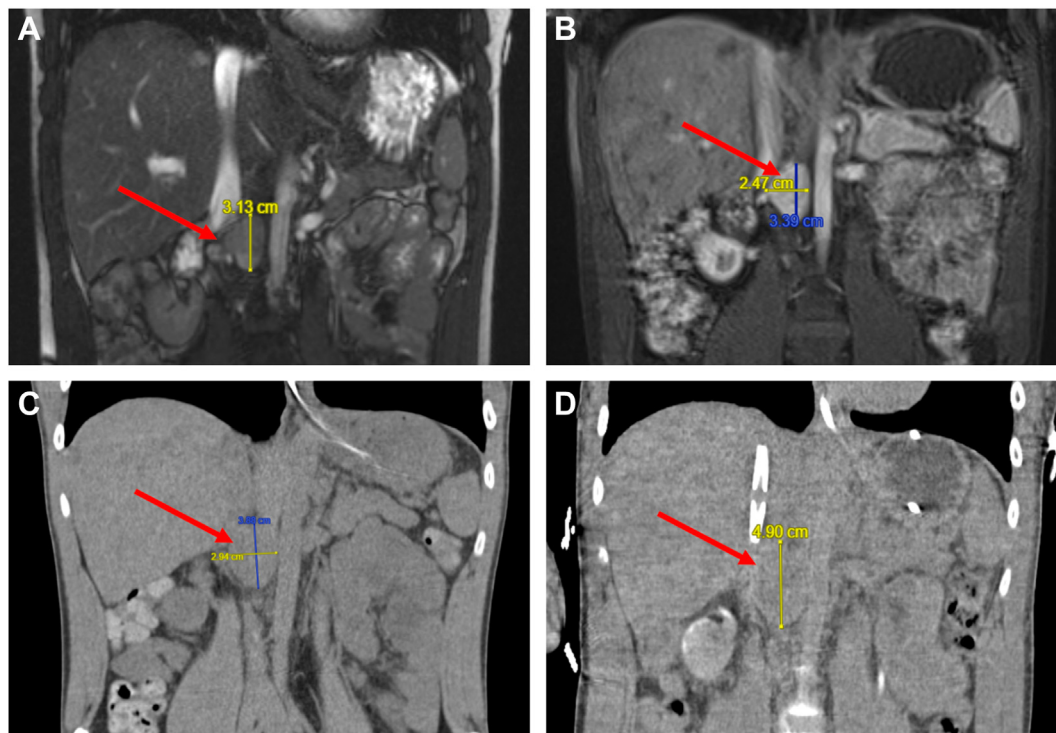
A, Cardiac magnetic resonance imaging 12/2017 – 3.13 cm mass; B, Magnetic resonance enterography 01/2019 – 3.39 cm mass; C, CT without contrast 08/2021 – 3.88 cm mass; and D, CT without contrast 04/2022 – 4.90 cm mass.
